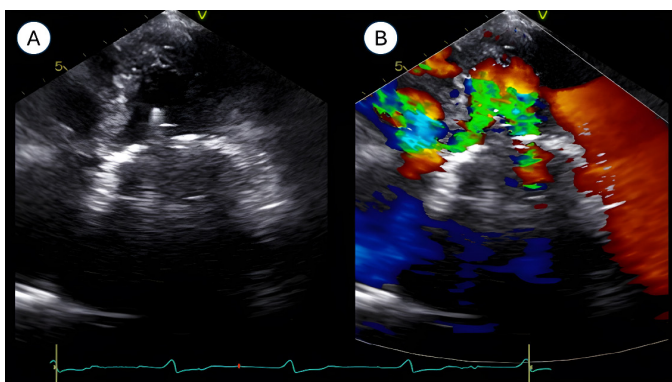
The echocardiogram shows the Starr-Edwards type mechanical mitral prosthesis, which is functioning normally with no pathological leaks. Proper movement of the ball within the cage is observed, as well as the absence of significant gradients or paravalvular regurgitation
